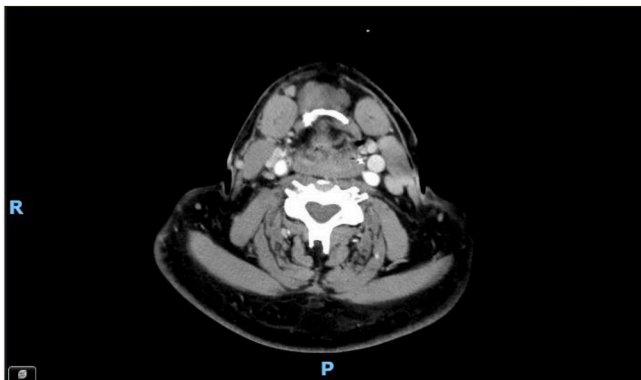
9 months-post-operative CT scan; no respiratory space can be seen, showing that the patient can only breathe with his trachea.
